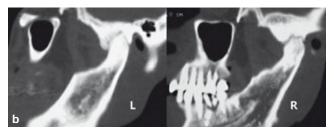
Coronal image (a) and sagittal image (b) of CT scan showing bilateral joint space narrowing, sclerosing and irregular proliferation of the condyle and fossa.
